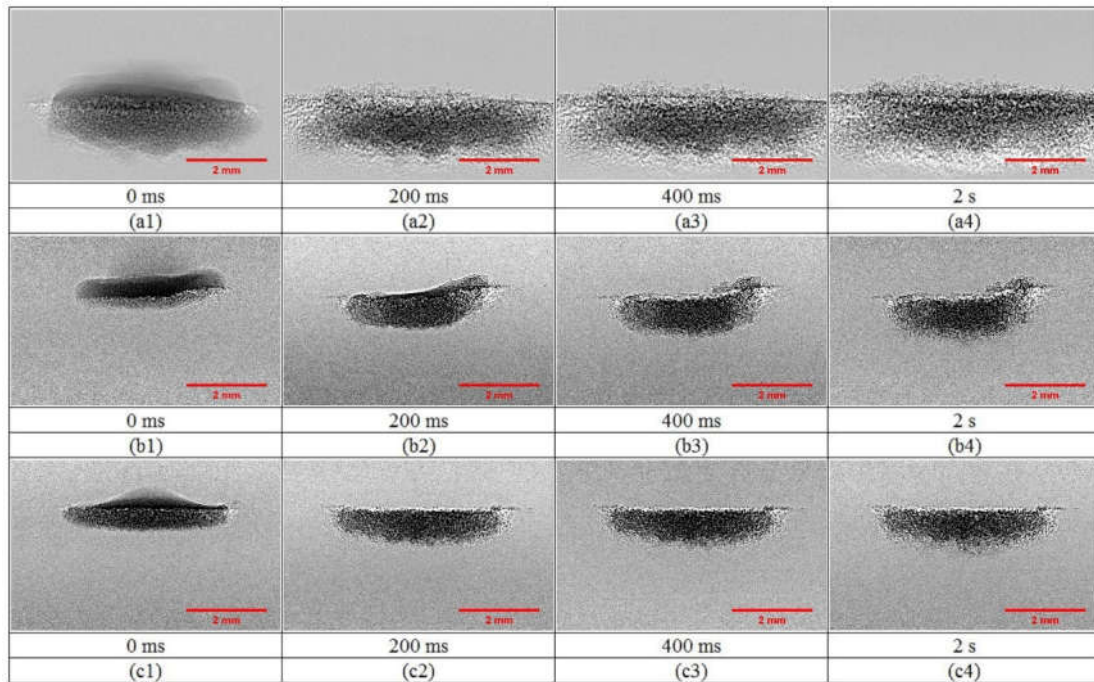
Time sequence X-ray images of the granulation process for MCC powder with (a1-a4) water, (b1-b4) isopropanol, (c1-c4) ethanol, as a liquid binder with a drop height of 2.5 cm and a droplet volume of 15 μl .
